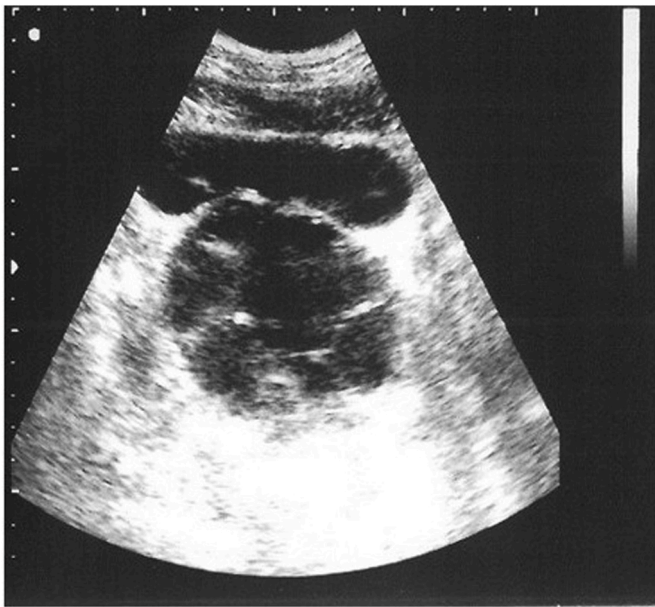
Pelvic ultrasound – bladder and cystic lesion with septa.
